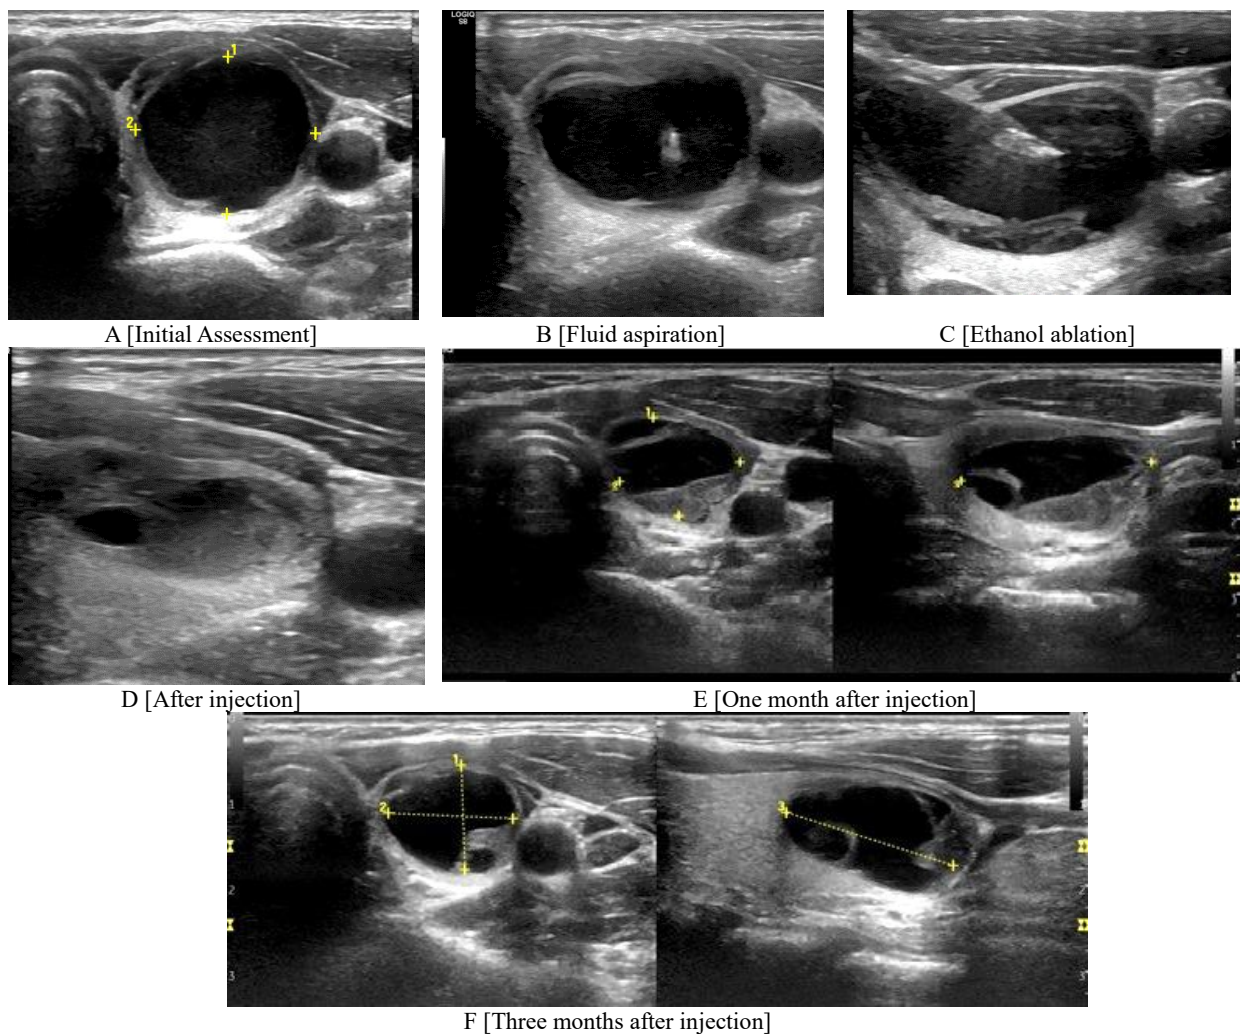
Ultrasound results of the second presented patient
